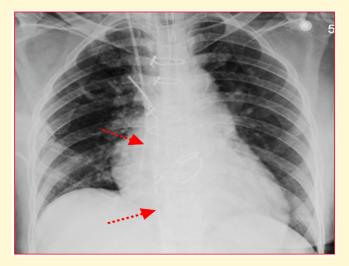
Frontal Chest Radiograph showing MDT insitu.
